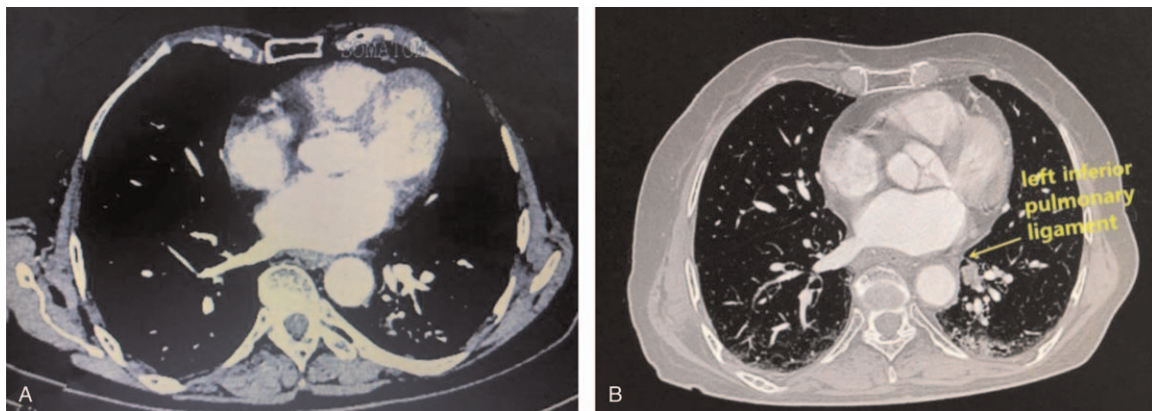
(A) Preoperative chest CT; (B) 7 months after the operation, chest CT showed left inferior pulmonary ligament lymph node enlargement. CT = computed tomography.
